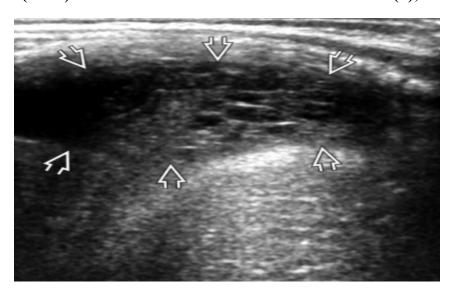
Chest ultrasound view of a 7 years old child showing pleural effusion containing echogenic debris and multiple loculations (white arrows).
